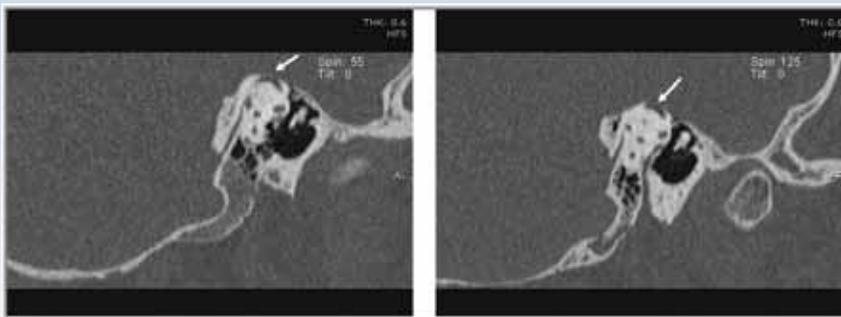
High resolution CT scan images in the Poschel orientation (parallel to the superior canal). Arrows point to the missing bone above the superior semicircular canal.
